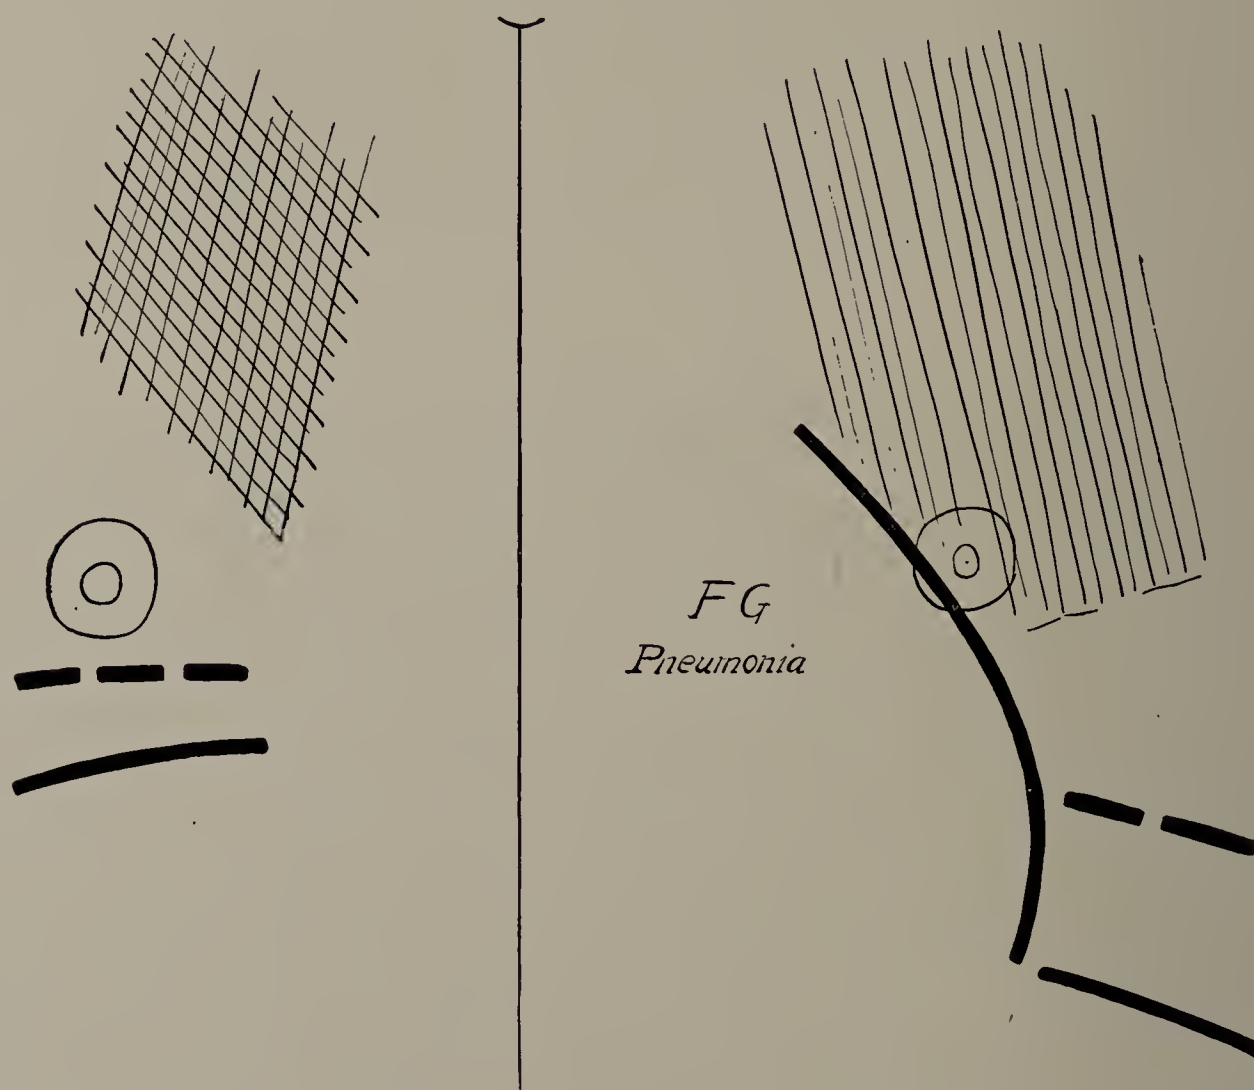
F. G. Pneumonia on both sides. Cut of X-ray tracing. Signs more marked on left side by X-rays than by auscultation and percussion; more marked on both sides by fluorescent screen than by X-ray photograph. (One-third life size.)
